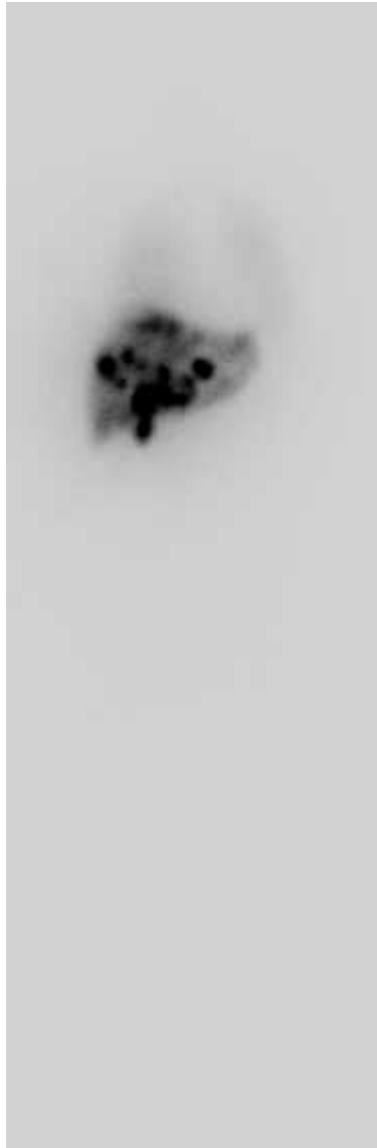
Quantitative whole body scintigraphy obtained 7 days post therapeutic in a 52-year-old man showing significant activity in the HCCs and only a faint lung uptake.
